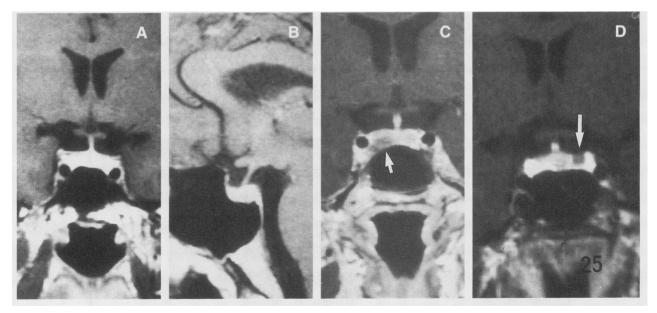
Gadolinium-enhanced magnetic resonance images are shown of the pituitary gland. A and B, Coronal and sagittal images show the normal, uniformly enhancing pituitary stalk and pituitary gland. C, A pituitary microadenoma appears as a low-intensity lesion in the inferior aspect of the right lobe of the gland (arrow). D, The pituitary microadenoma appears as a low-intensity lesion between the left lobe of the pituitary and the left cavernous sinus (arrow). (Photographs courtesy of David Norman, MD.)
